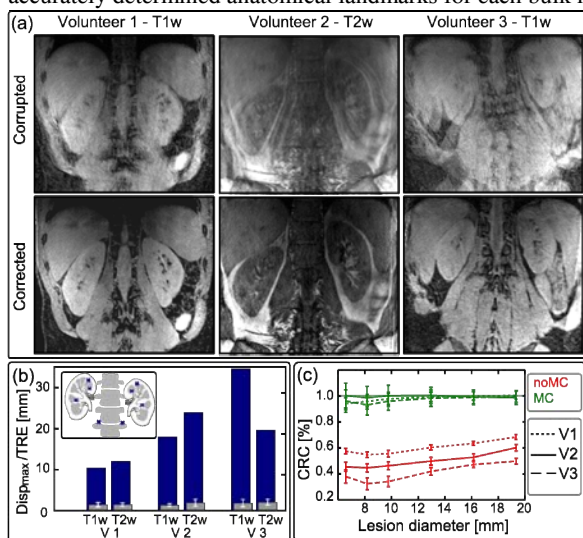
(a) Motion corrupted and corrected T1w and T2w MR images for 3 volunteers (V). (b) Max displacement (blue) and Target Registration Error (TRE, gray) of obtained motion fields (landmarks). (c) Contrast recovery coefficient (CRC) relative to motion free reference comparing images without (noMC) and with (MC) motion correction.
